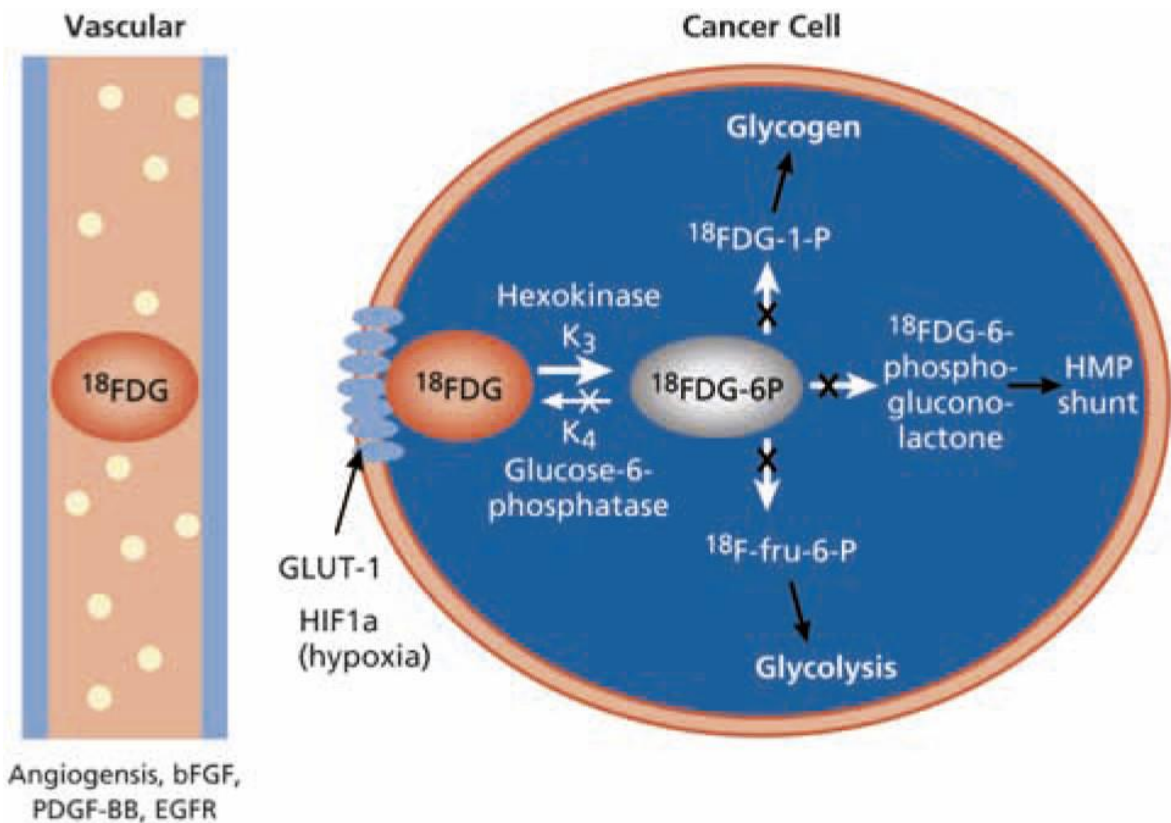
Display of the metabolism of ^{18}F -FDG [65].
